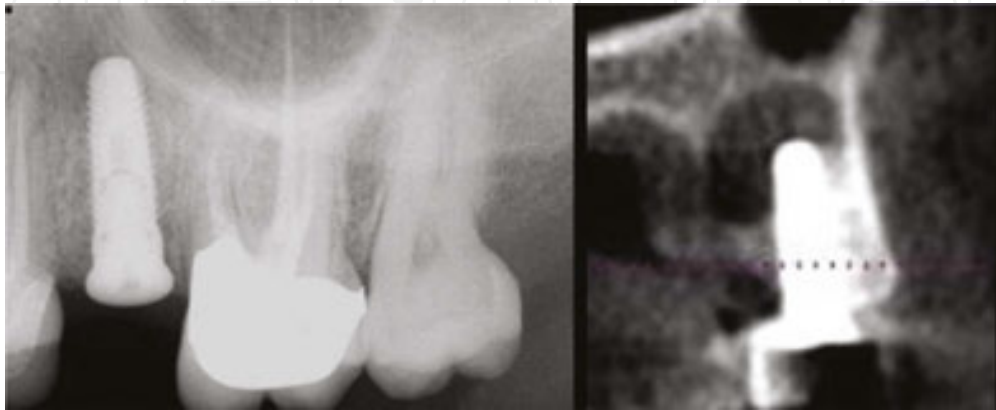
This implant was placed and appeared to integrate well, but a check radiograph at a later time showed apical pathology. The implant was removed, the region debrided and allowed to heal.
